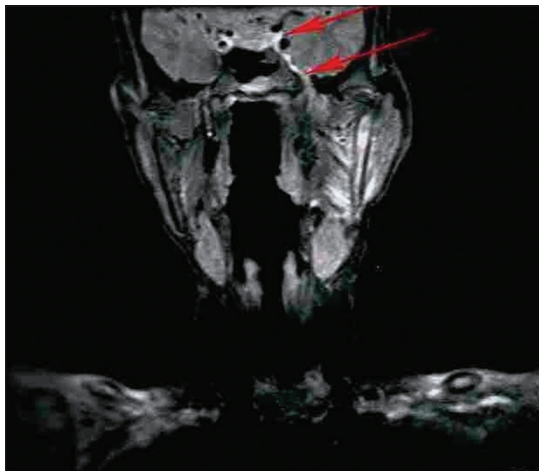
Peri-neural spread on magnetic resonance imaging image (coronal view)
